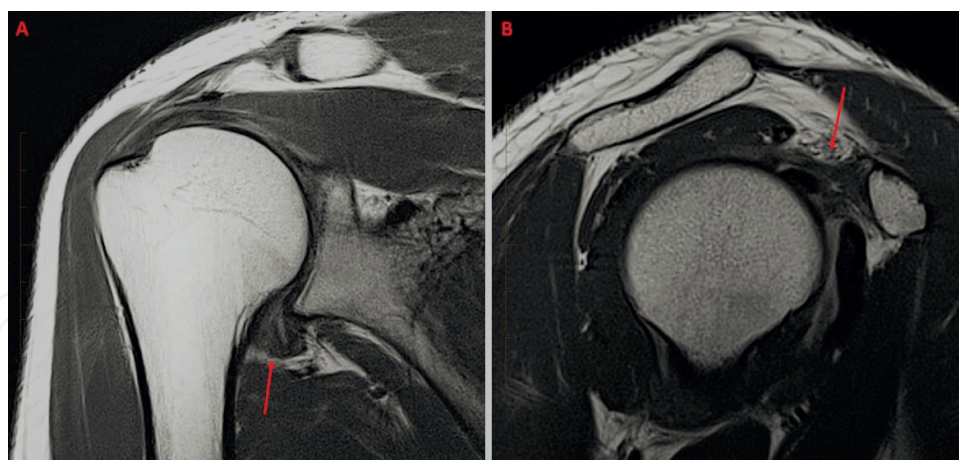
Frozen shoulder at MRI. Coronal PD (A): thickening of the axillary recess of the glenohumeral joint; sagittal PD (B): inflammation in the rotator cuff interval.
